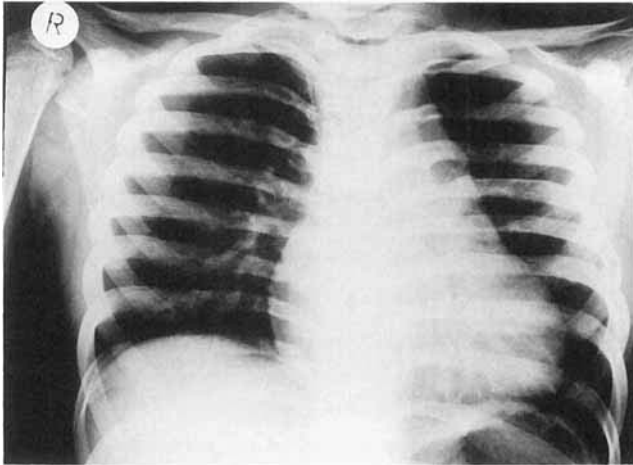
Frontal roentgenograph of the proposita's chest with dense striation of the humerus, acromion, and ribs, and widening of the dorsal parts of the ribs.
